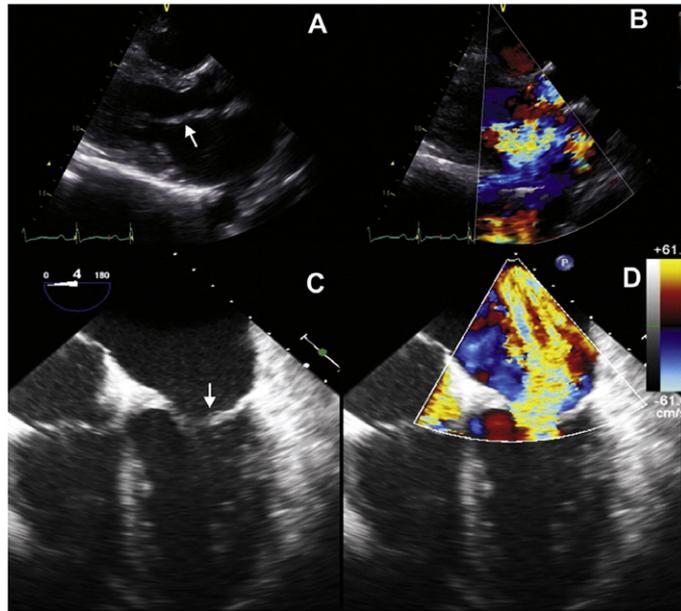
Abnormally thickened mitral valve leaflets with restricted opening on echocardiography (A: parasternal long-axis view on transthoracic echocardiography; C: mid-esophageal four-chamber view on transesophageal echocardiography; arrows point to thickened mitral valve leaflets). Severe, torrential mitral regurgitation on color Doppler analysis (B: parasternal long-axis view on transthoracic echocardiography; D: mid-esophageal four-chamber view on transesophageal echocardiography).
